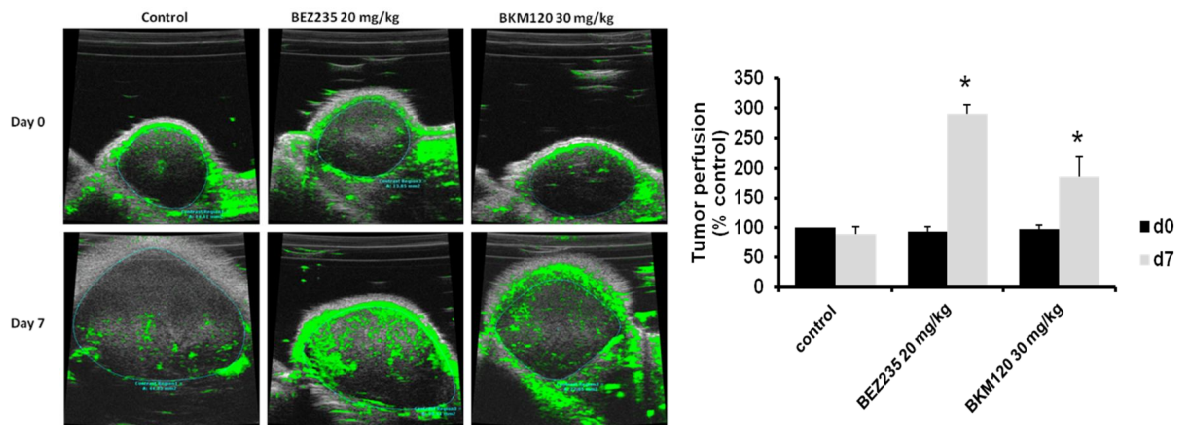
Perfusion changes before and after seven days of BKM120 (now Buparlisib) and BEZ235 (Fokas *et al.*, 2012). A significant increase in perfusion (measured by microbubble ultrasound) occurs after both BKM120 and BEZ235, but with no significant change in the control group.
